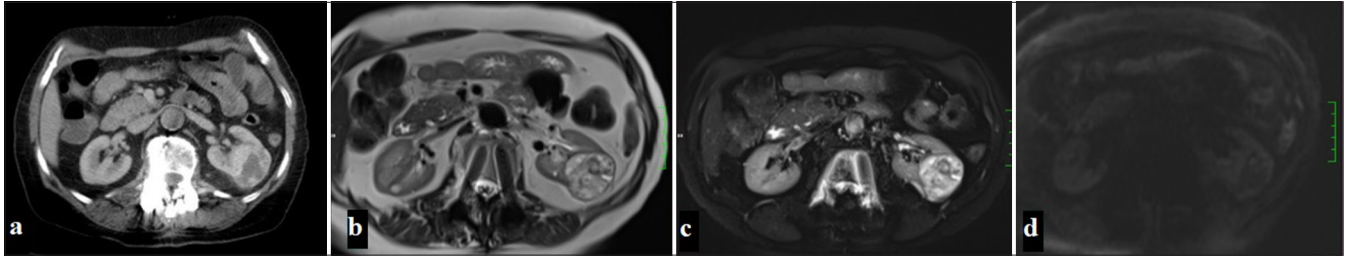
(a) A 65-year-old woman with a mass in the left kidney observed on CT in the portal phase, (b) On MRI, the mass appears heterogeneously hyperintense on T2-weighted and fat-suppressed T2-weighted images, (c) while areas within the mass demonstrate focal diffusion restriction on diffusion-weighted imaging (DWI) (d) and apparent diffusion coefficient (ADC) maps.
